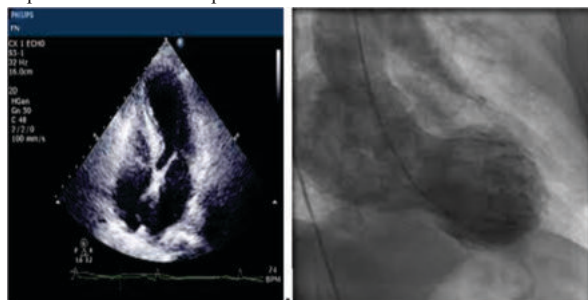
(a) Echocardiography at the time of presentation.; (b) LV Angiogram showing ballooning of left ventricle during systole.
